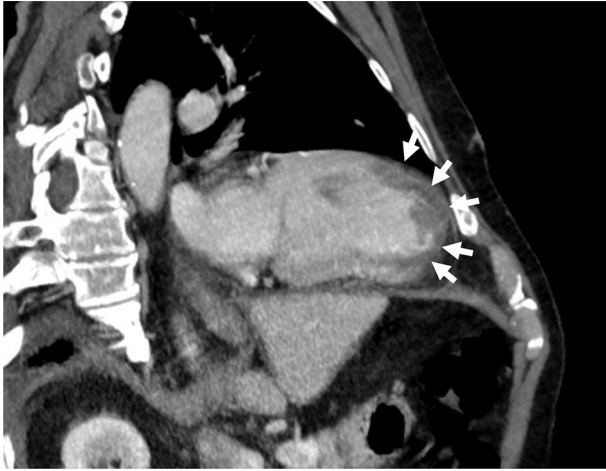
CT scan of the heart following iodine-contrast injection, 2 chamber view. Please note widespread subendocardial filling defect of the apex and anterior wall of the left ventricle (dark area in myocardium lightened by iodine contrast; white arrows).
